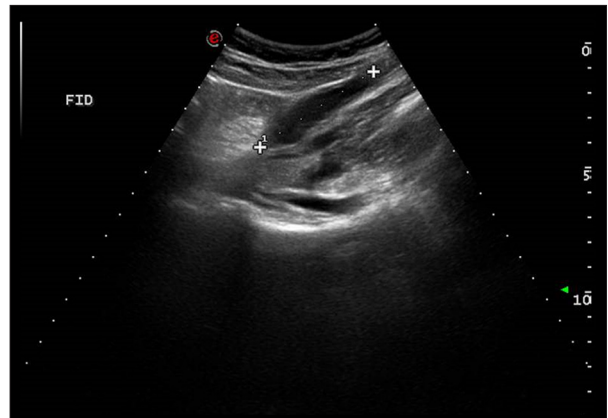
Abdominal ultrasound showing an appendix 5.5 cm long, dilated, and distended by an anechogenic material with wall thickening.
